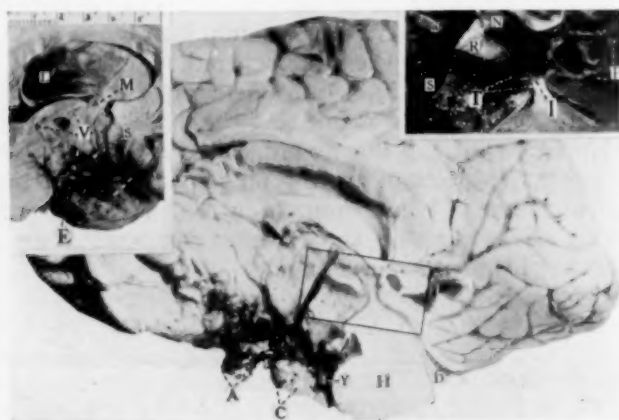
Case III. The central photograph of the mesial surface of the right half of the brain shows the calcified mass (C) which produced the shadow in the X-ray. At A is a second mass of tumor tissue. The squared area is shown enlarged in the right upper insert. The cystic tumor has extended above, displacing the floor of the third ventricle (R) upward, almost obliterating the space of the ventricle, which is reduced to the area between R and N. Posteriorly the wall of the cyst (T) has encroached upon the aqueduct of Sylvius (J). Anteriorly the floor of the third ventricle becomes deficient at (A). In the left half of the brain (left upper insert) the wall (V) of the cyst is deficient above and the widely dilated foramen of Monro (M) is seen leading into the dilated lateral ventricle (L). The extent of solid tumor (most of which has been removed) is shown at E. Blocks taken at S. P=pineal. H=pons. D=fourth ventricle. (Y)=basilar artery.
